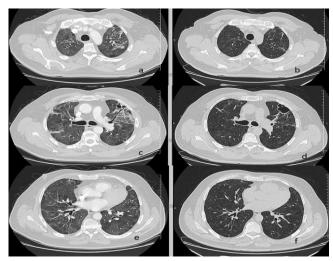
Chest CT axial sections showing persistent bronchiectatic changes despite persistent regression in fibrotic findings at the third month post-COVID (a,c,e) and 11th month post-COVID (b,d,f)
